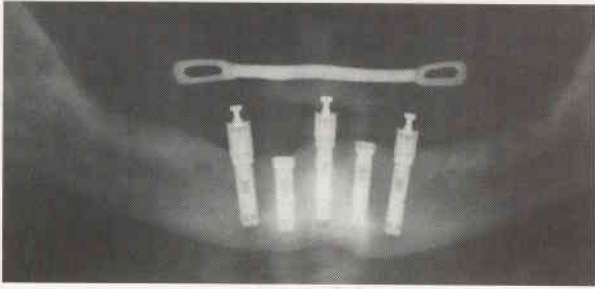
Radiograph of the provisional prosthesis in place, screw retained to the midline and to distal implants. The adjacent interproximal implants were submerged in the traditional fashion. The addition of a prefabricated lingual bar to the prosthesis provides rigidity and strength for the cantilevered segments of the 12-tooth provisional prosthesis, which extends distally to include the first molar.
